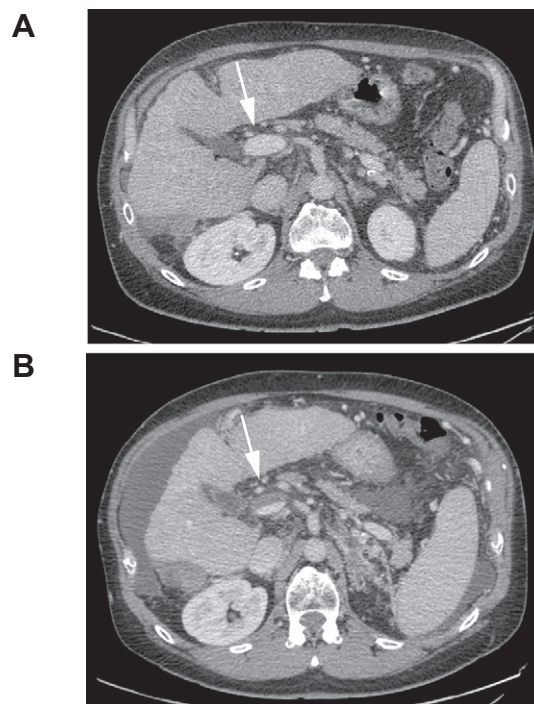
Helical computed tomography showing patent portal vein (A, white arrow) in a candidate for liver transplantation with alcohol-related cirrhosis at evaluation. Six months later, follow up computed tomography in the same patient shows the occurrence of *de novo* portal vein thrombosis. The thrombus is partial and involves the trunk of the portal vein (B, white arrow).
